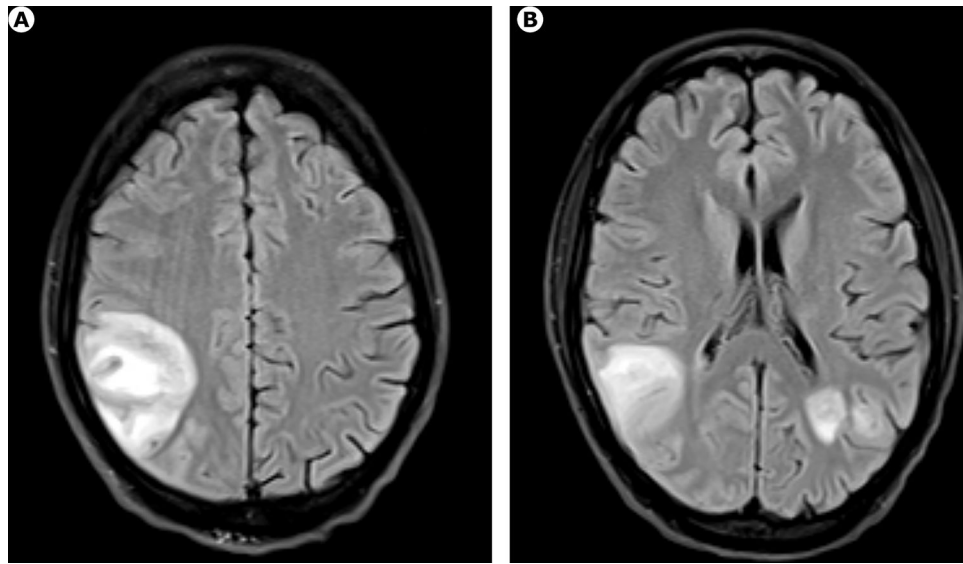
MRI brain on hospital day 6
